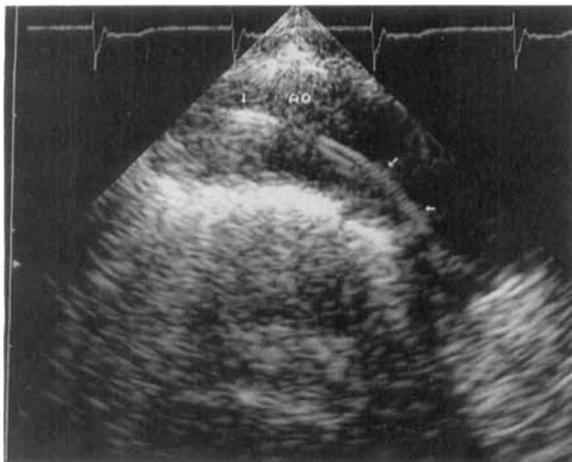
Transesophageal echocardiography in the mid-upper esophagus with 135° angle demonstrates the pacemaker wire (arrows) crossing the aortic valve, entering the left ventricle. There was no aortic regurgitation. AO = proximal ascending aorta; LA = left atrium.
